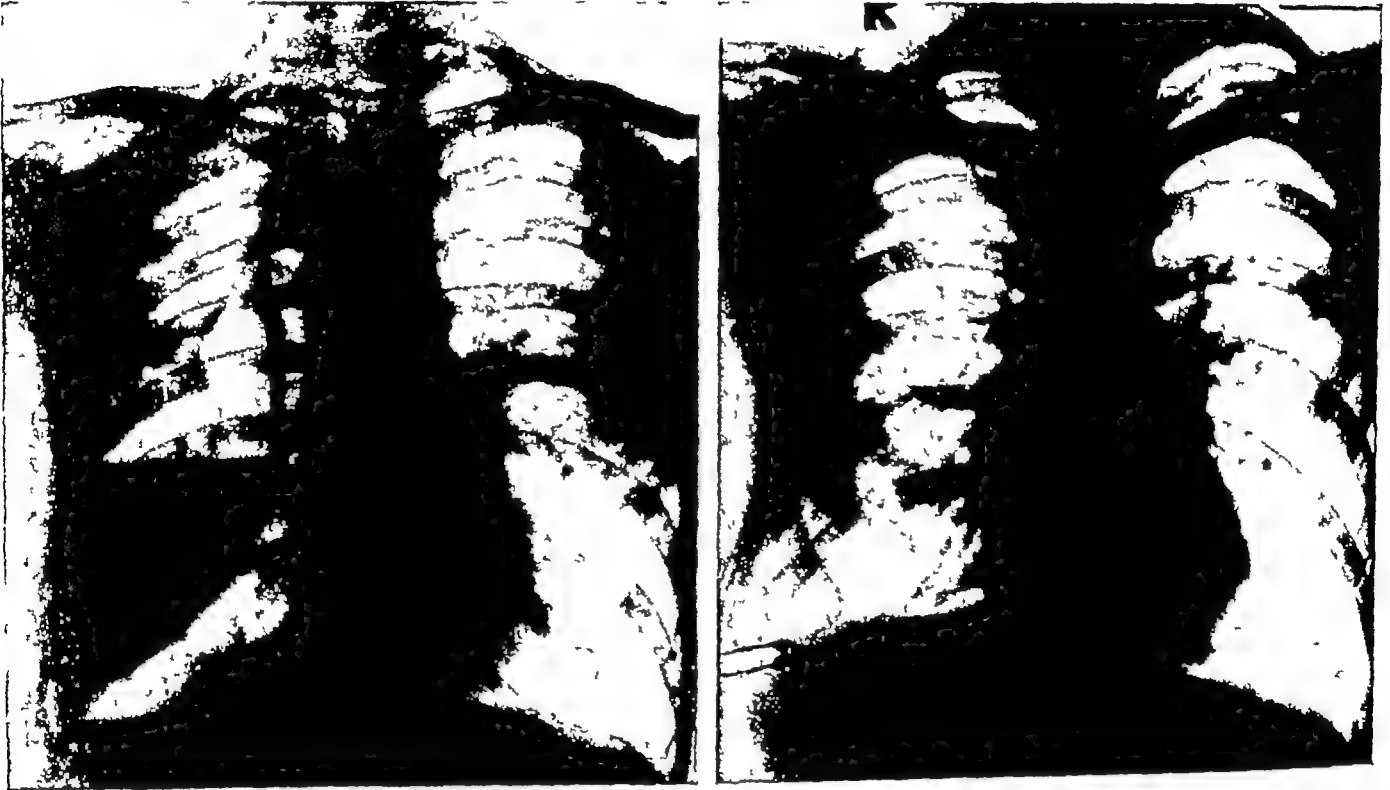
Radiographs of a male adult with pulmonary tuberculosis, (a) complicated by a spontaneous pneumothorax, (b) satisfactory lung re-expansion after drainage
